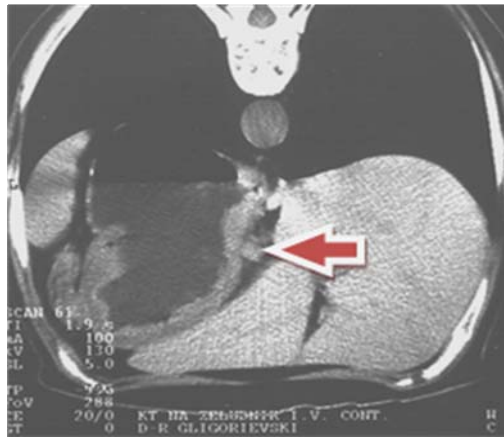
Low-grade MALT lymphoma of the stomach: Axial contrast-enhanced CT scan obtained through the stomach shows segmental and mild wall thickening of the body of the stomach, with minimal contrast enhancement. MS deposit in the perigastric lymph node
